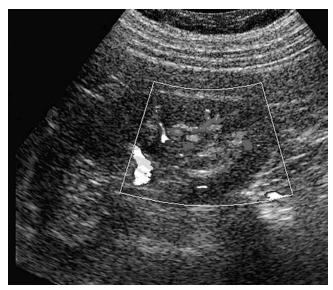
Sagittal Doppler image (see color plate 6).
